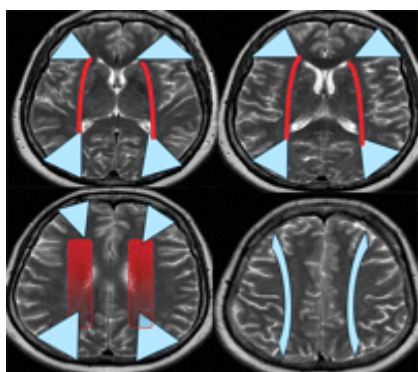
Color overlays on axial T2-weighted magnetic resonance (MR) images of normal cerebrum show probable locations of external (blue) and internal (red) border zone infarcts.
